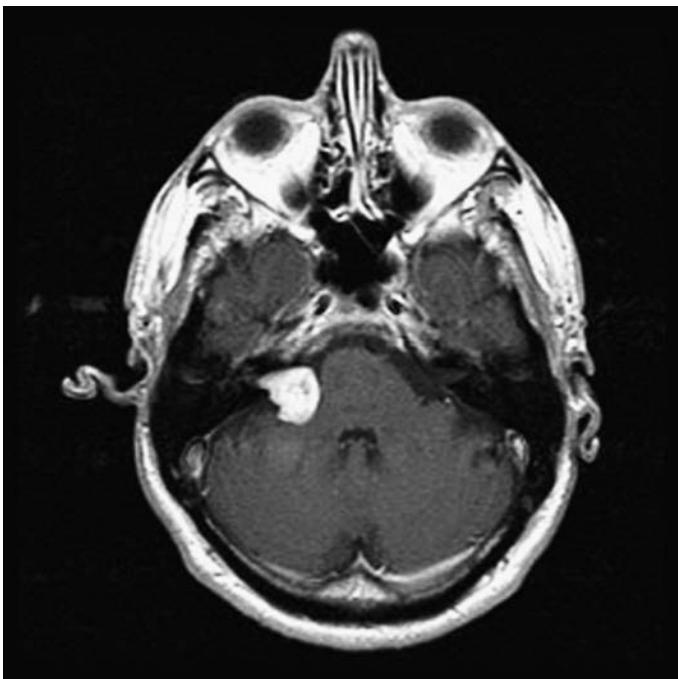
Postgadolinium MRI of a right vestibular schwannoma. The tumor can be seen to involve the internal auditory canal.
